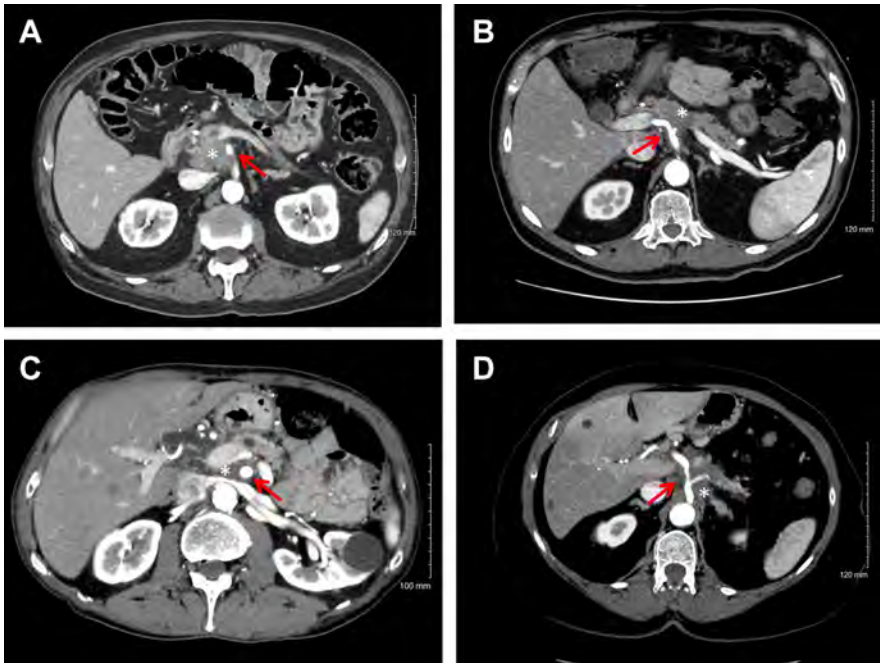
Computed tomography axial images representing locally advanced pancreas cancer. (A) Locally advanced type A tumor with SMA (*arrow*) encasement greater than 180° but less than 270° . (B) Locally advanced type A tumor with celiac axis (*red arrow*) encasement greater than 180° without involvement of the aorta. (C) Locally advanced type B tumor with SMA (*arrow*) encasement greater than 270° . (D) Locally advanced type B tumor with celiac axis (*arrow*) encasement extending to the aorta. Tumor is marked by *asterisk*.
